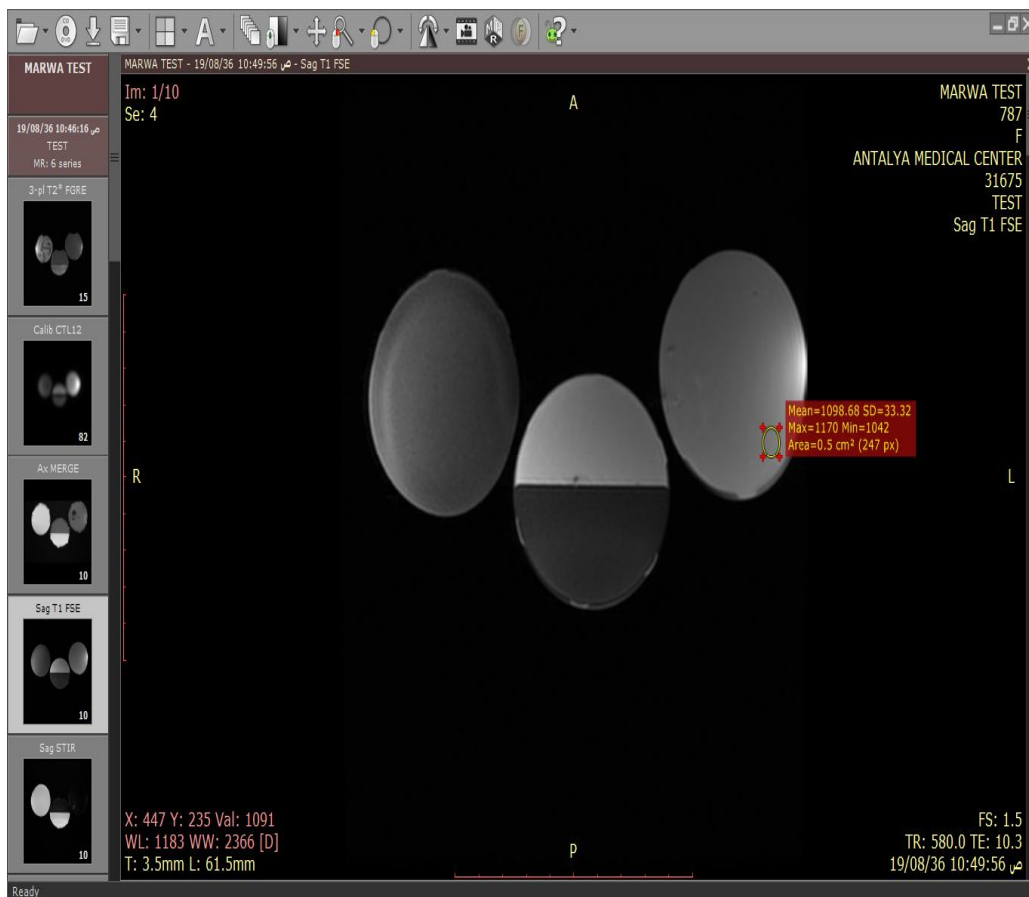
Sag T1 image taken by GE MRI 1.5T in Antalya medical center
